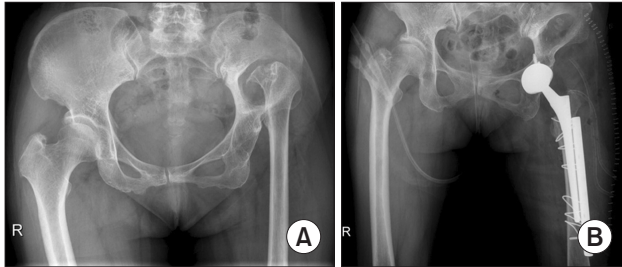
(A) Preoperative hip anteroposterior radiograph showed Crowe type IV developmental dysplasia of the hip in the left hip joint. (B) Postoperative hip anteroposterior radiograph after total hip arthroplasty.
